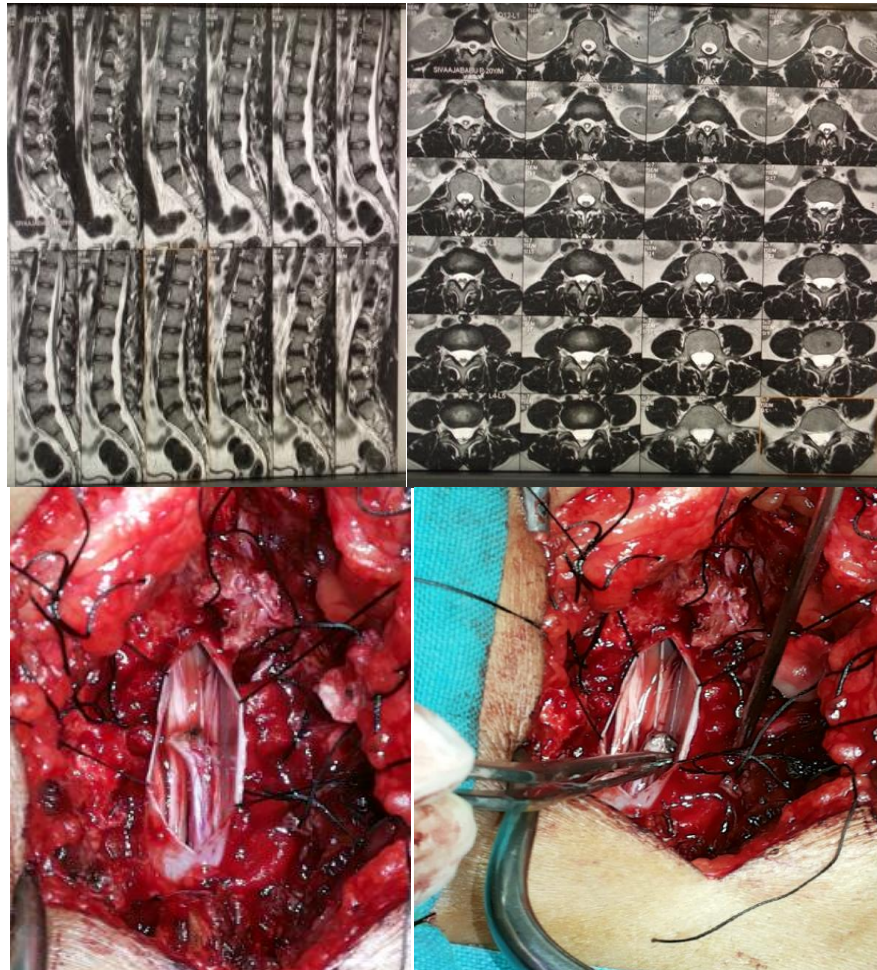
6: Showing T- 2 MRI image of low lying tethered cord ending at l - 3 in two patients
